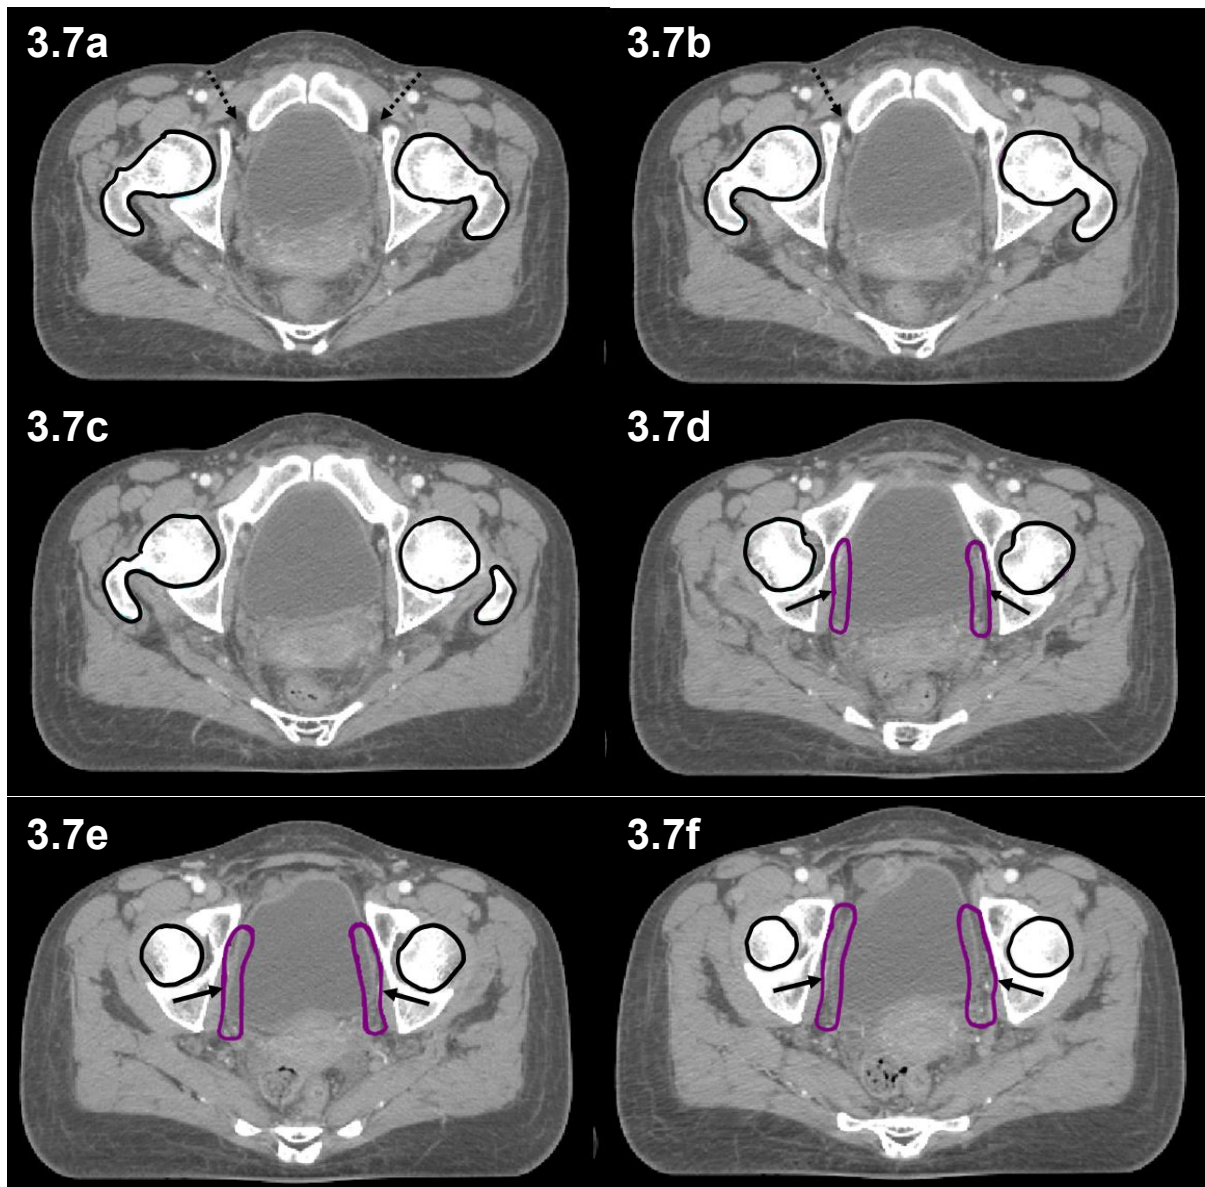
Transverse CT showing the caudal slice of CTV2 (outlined and arrowed in d-f). This is at the level of the mid-femoral heads (outlined) and approximately 1cm superior from the top of the obturator foramen (dashed arrows in a and b).
